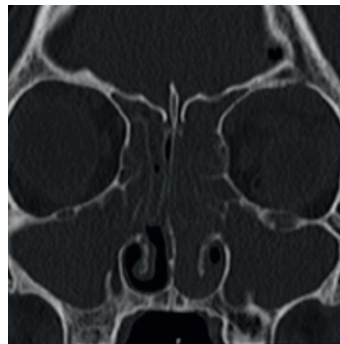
CT: Pansinusitis, with practically complete filling of the different sinus cavities, with only slight aeration at the posterior ethmoid and left sphenoid level.
